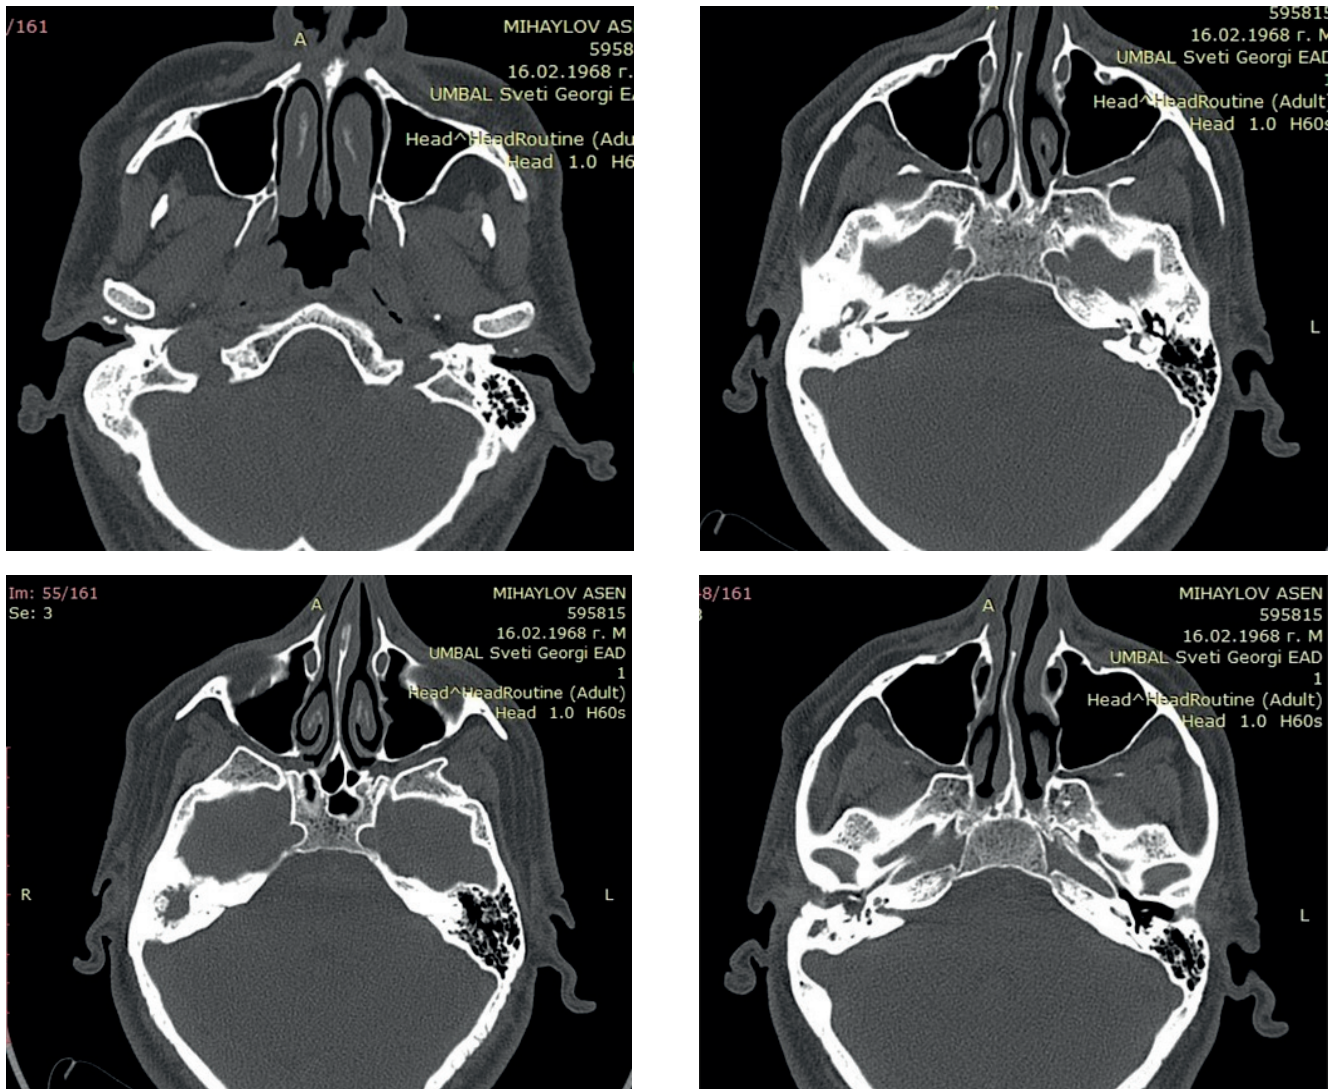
Preoperative CT images of the patient.
